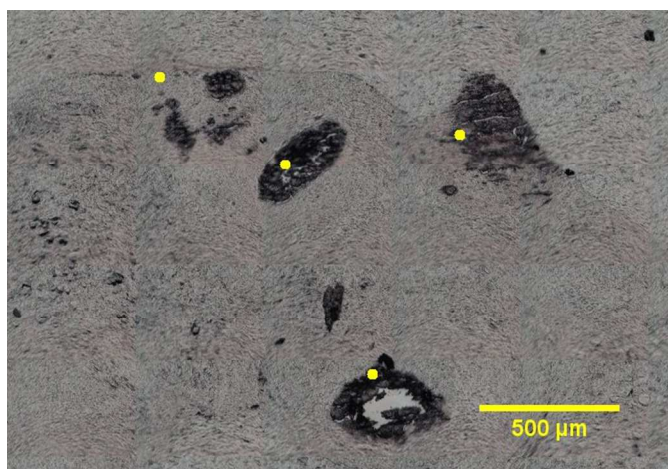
CT-derived coordinates of four calcifications overlaid on a white light image of an unstained section
